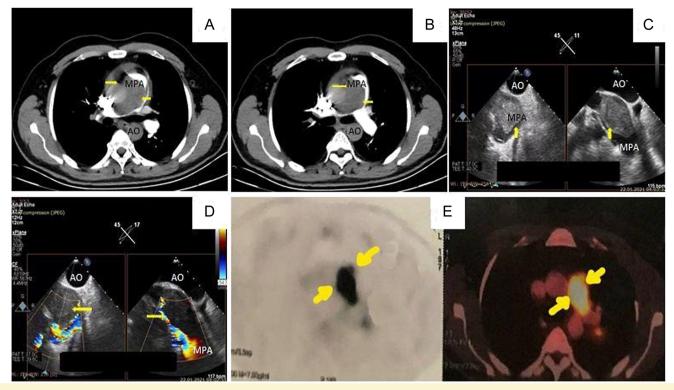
A, B. Contrast-enhanced computed tomography (CT) of the thorax showed a pulmonary artery mass (arrows) causing a filling defect. C. Transesophageal echocardiography (TEE) revealed a mass (arrows), attached to the pulmonary artery wall. D. Color flow doppler images of the pulmonary artery was seen. E. Fluorodeoxyglucose positron emission tomography (FDG-PET) showed a mass of soft tissue density with hypermetabolism (yellow arrows). Written informed consent was obtained from the patient. AO, aorta; MPA, main pulmonary artery.
